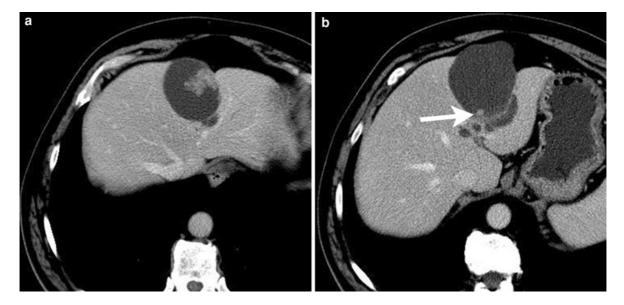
Intraductal-growing intrahepatic CC. a, b Axial CT images show multiple papillary tumors (*arrow*) that aneurysmally distend the affected duct due to excess mucin production.
